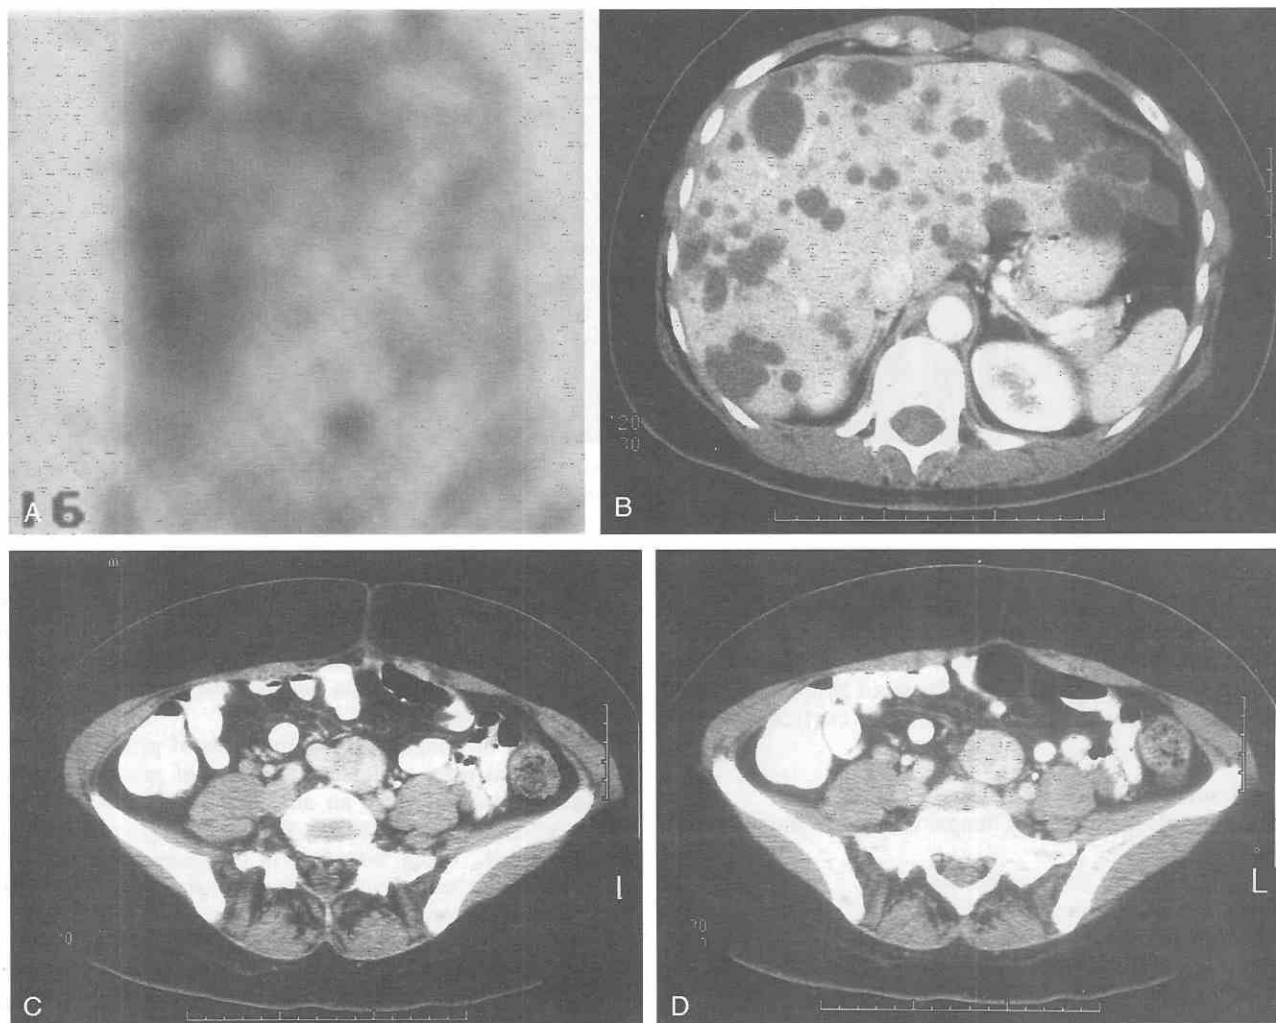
Pheochromocytoma. A, Whole-body metaiodobenzylguanidine (MIBG) scan demonstrates uptake in the lower abdomen and upper pelvis. B–D, Contrast-enhanced CT scans of the abdomen and pelvis demonstrate normal-appearing adrenal glands; multiple cysts are present in the liver. A solid, 3-cm enhancing mass at the aortic bifurcation is compatible with a pheochromocytoma in the organ of Zuckerkandl. This tumor was successfully resected. (Courtesy of Mayo Foundation.)
